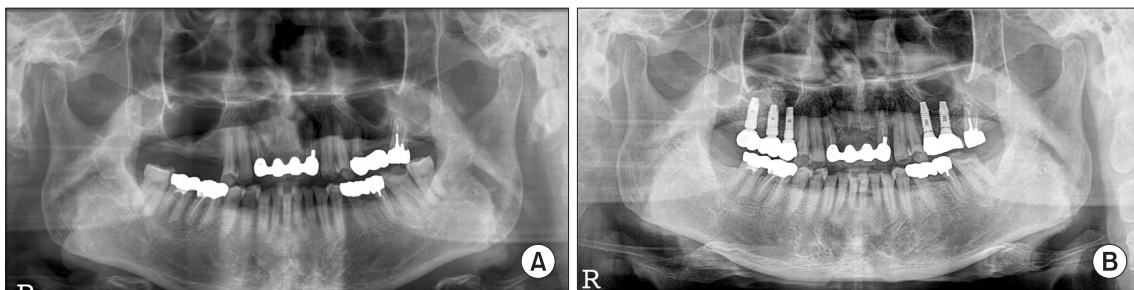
Change in alveolar bone height (Case 2). A. Preoperative panoramic radiograph. B. Panoramic radiograph 59 months after sinus-bone graft.
